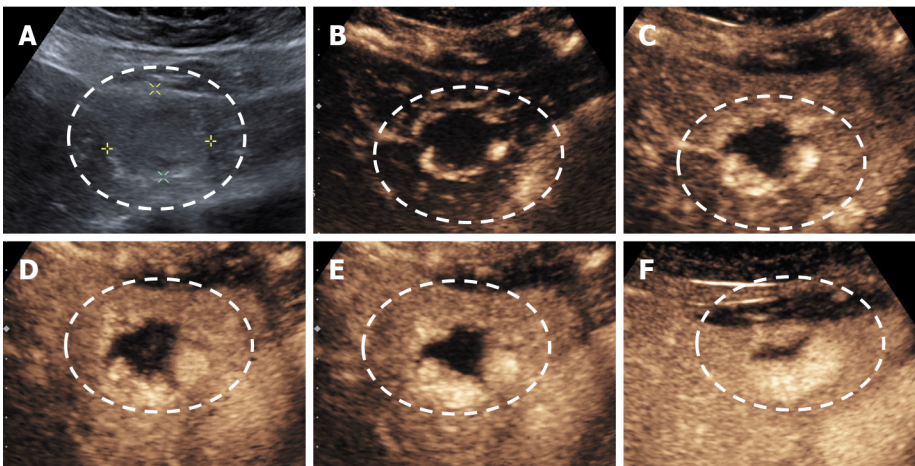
Example of hemangioma with echoic border. A: B-mode ultrasound; B-F: Typical pattern of enhancement: Peripheral nodular enhancement in arterial phase (B and C) centripetal filling (D and E) and incomplete enhancement in late phase (F).
